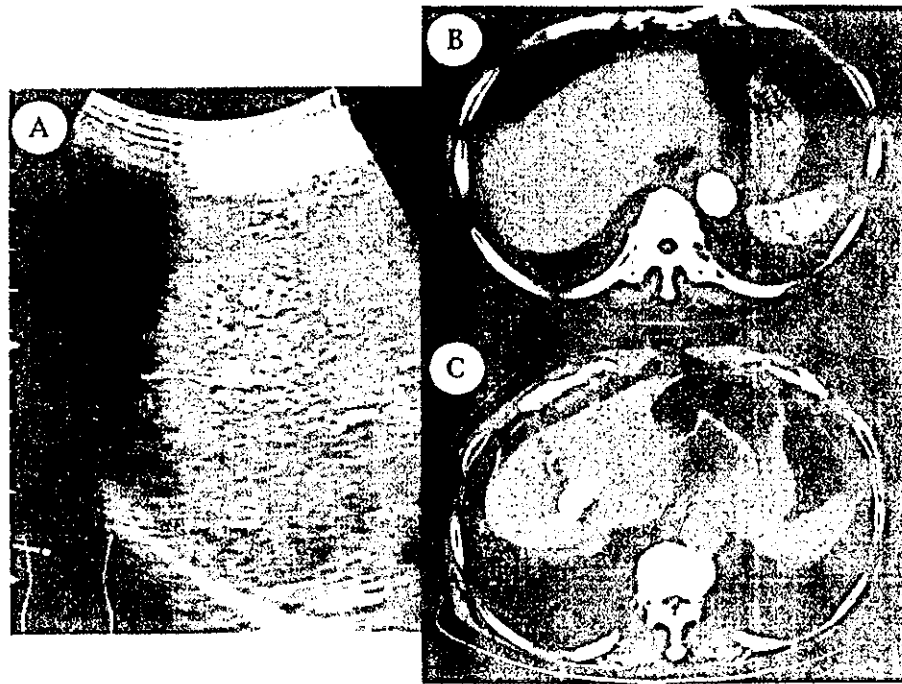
US and CT images of HCC (2.5 cm) located in the S8 region of the liver. Although the HCC was not detected by US before PELIT (A), it was clearly demonstrated by dynamic CT (B). PELIT was performed under the US guidance based on the judgment of the CT findings. Accumulation of lipiodol in the whole tumor was observed by plain CT (C).
